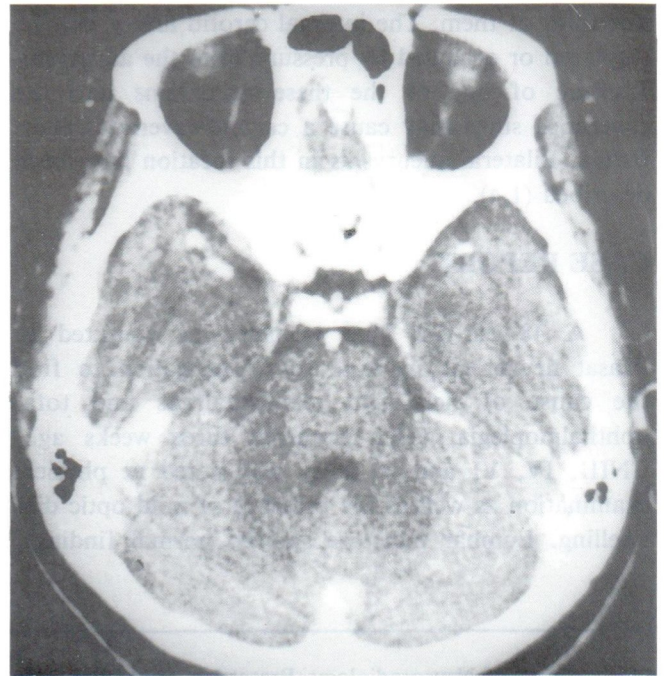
Pre and post contrast axial CT scan of the brain revealed exophthalmos without bulging of the cavernous sinuses.
